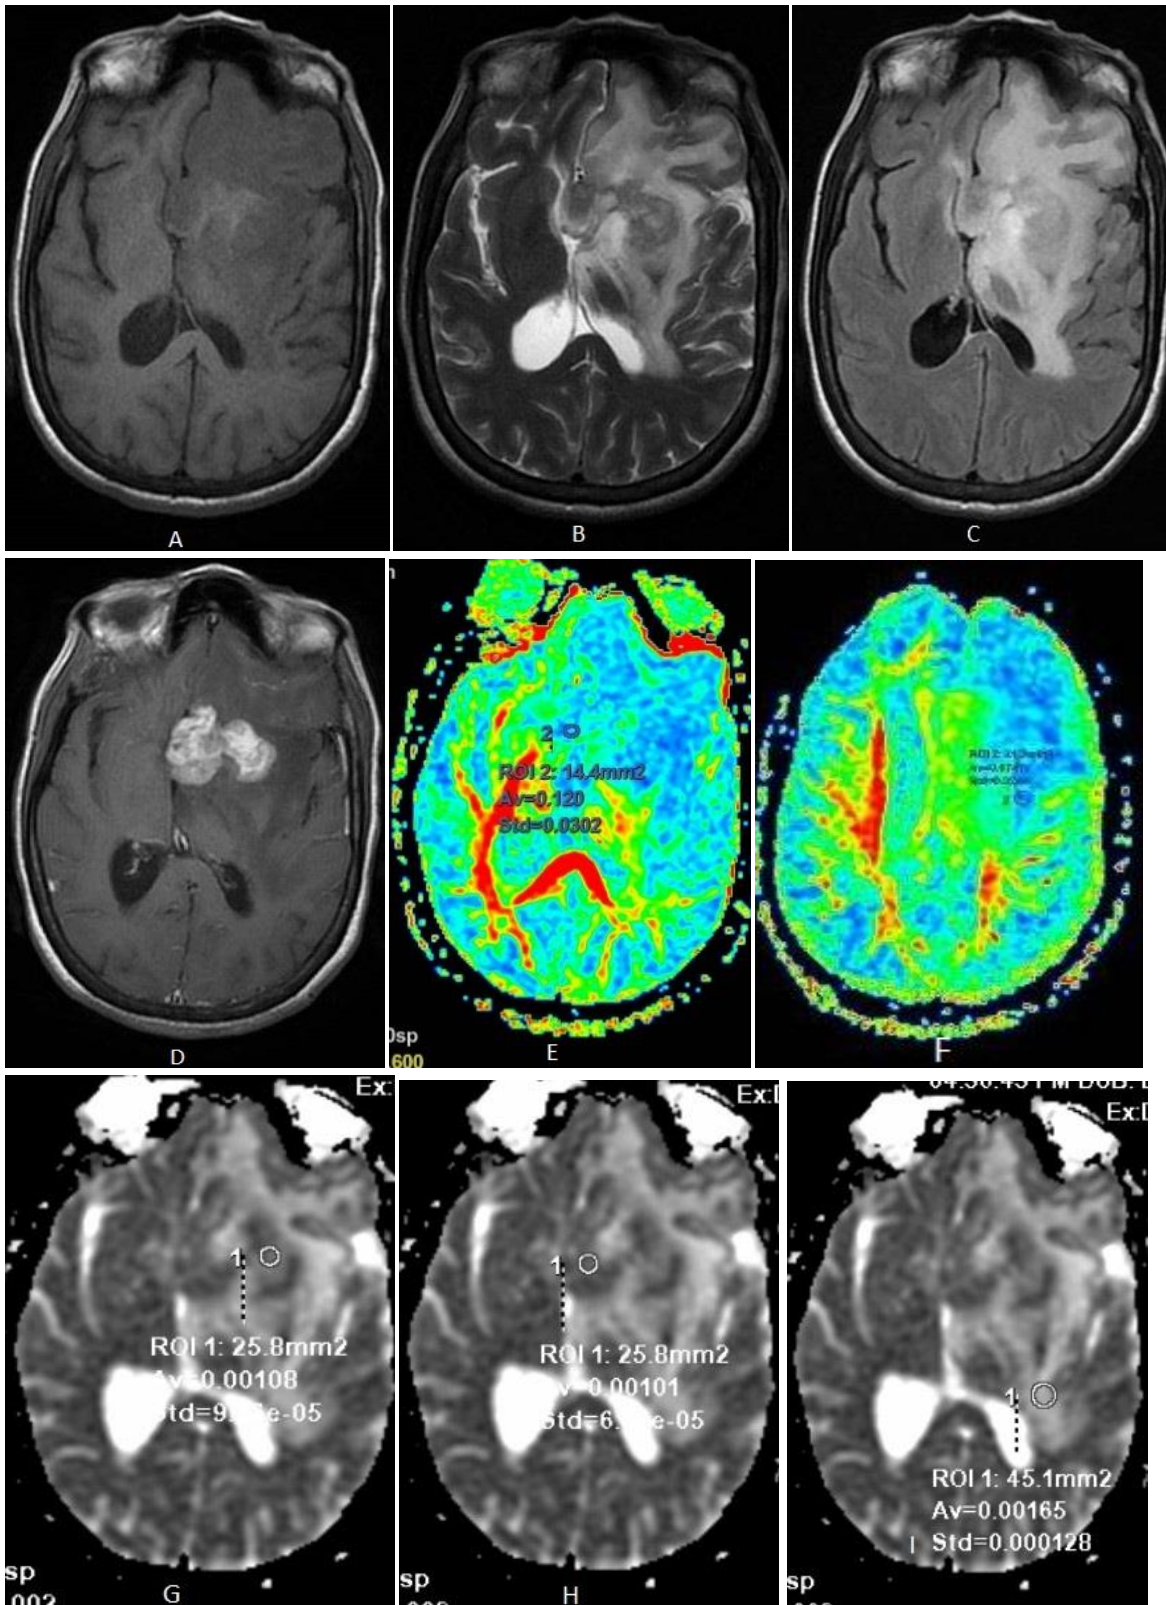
Female patient 30 years old, pathologically proved high grade glioma (A), (B) and (C) images Axial T1, T2 and FLAIR images respectively, showing left temporal intra axial lesion with surrounding vasogenic edema and heterogeneous post contrast enhancement (D). (E) and (F) FA map with two regions of interest measured within the enhancing part of the tumor and within the immediate peri-tumoral edema demonstrate reduced FA value in the immediate peri-tumoral edema, (G) and (H) ADC map with two regions of interest measured within the enhancing part of the tumor and (I) within the immediate peri-tumoral edema demonstrates slightly decreased ADC within the immediate peri-tumoral edema.
